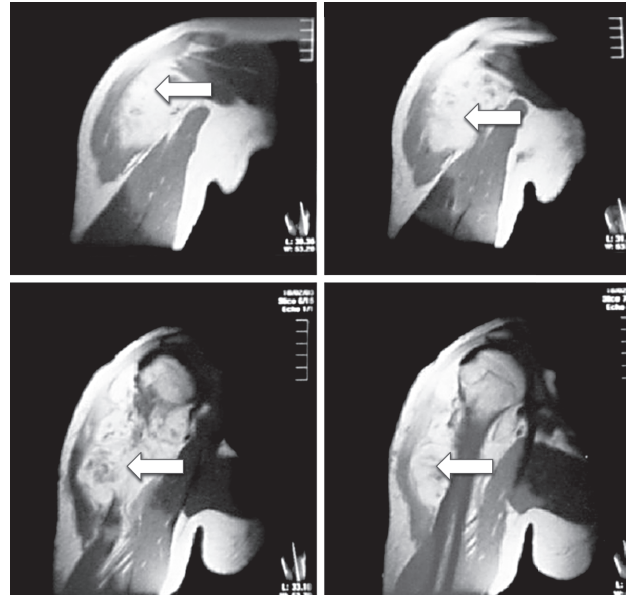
Case No. 20 was referred to us with an osteosarcoma of the proximal humerus. As shown at MRI (arrows), the tumor is involving the deltoid muscle after inappropriate biopsy undertaken elsewhere.
